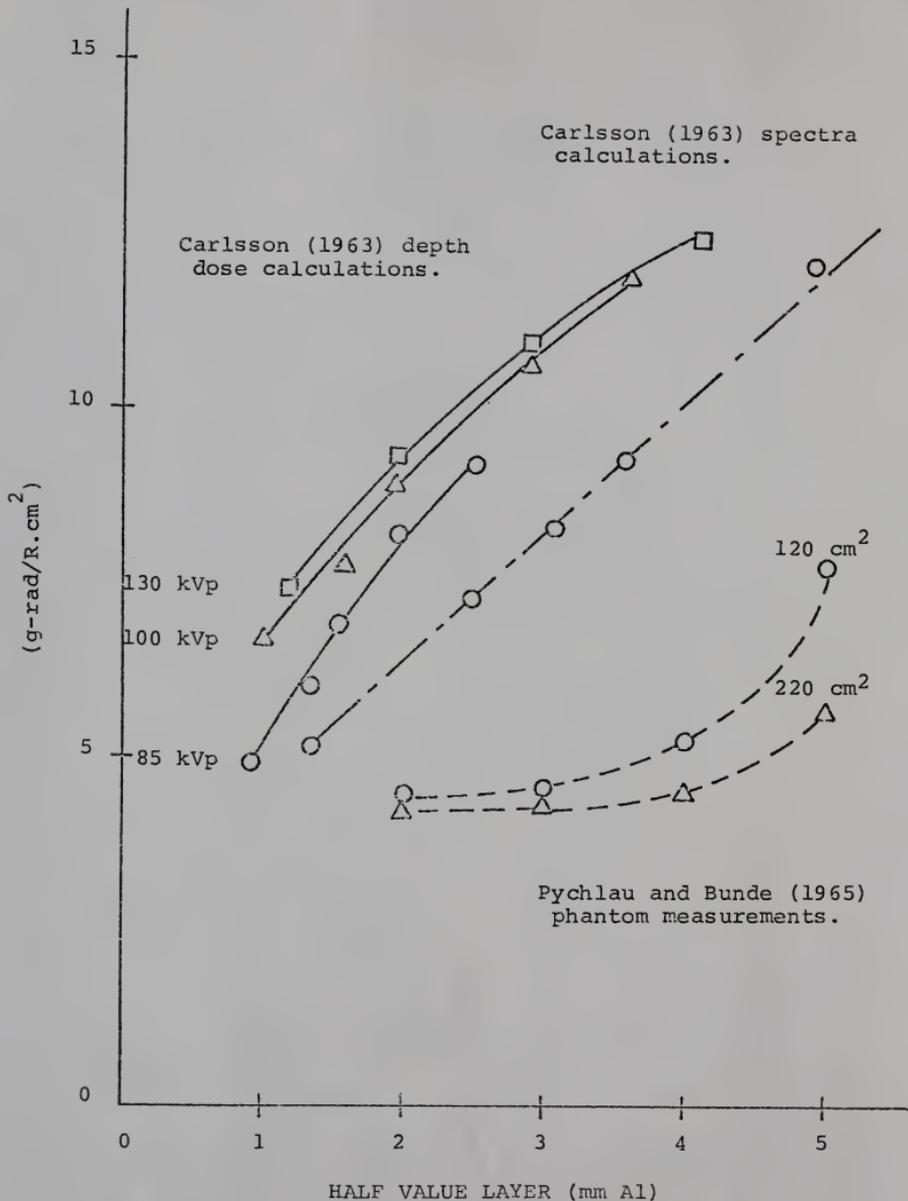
Integral Dose per EAP as a Function of X-ray Beam Quality Reported by Carlsson (1963) and Pychlau and Bunde (1965).
